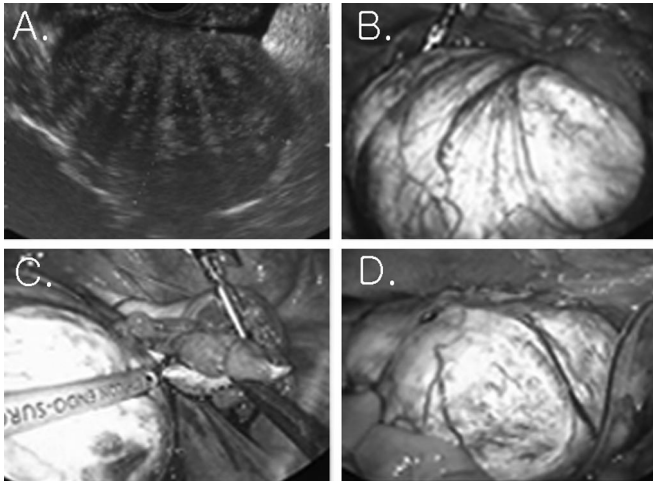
(A) Transvaginal ultrasonographic scan of the fibroma showing the hypoechoic image that cannot be distinguished easily from uterine myoma preoperatively; (B) Laparoscopic view shows the right ovarian fibroma with whitish color and smooth surface; (C) The tumor is being resected away from the right ovary using a Harmonic shears; (D) We are putting the resected fibroma into an endobag. The tumor can be safely removed by using an endobag.
